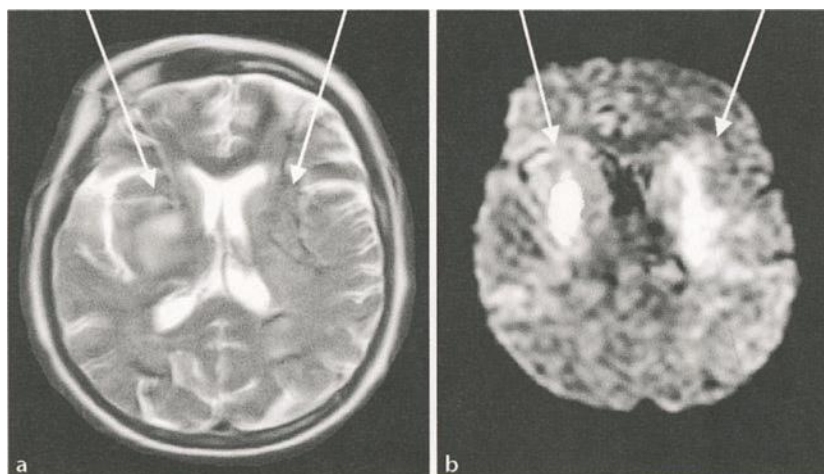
T2-WI (a) and DWI (b) of a subacute ischemic infarction on the right and a hyperacute ischemic infarction on the left, which is not shown on T2-WI but only on DWI. b The DWI shows a strong hyperintensity on the right, which is due to a loss of diffusion and a T2-effect of edema as seen in a (arrows). The lesion in the left MCA territory, seen only on the DWI (b) and not on T2-WI (a) is due to diffusion impairment only and depicts a hyperacute ischemic infarction (20)
